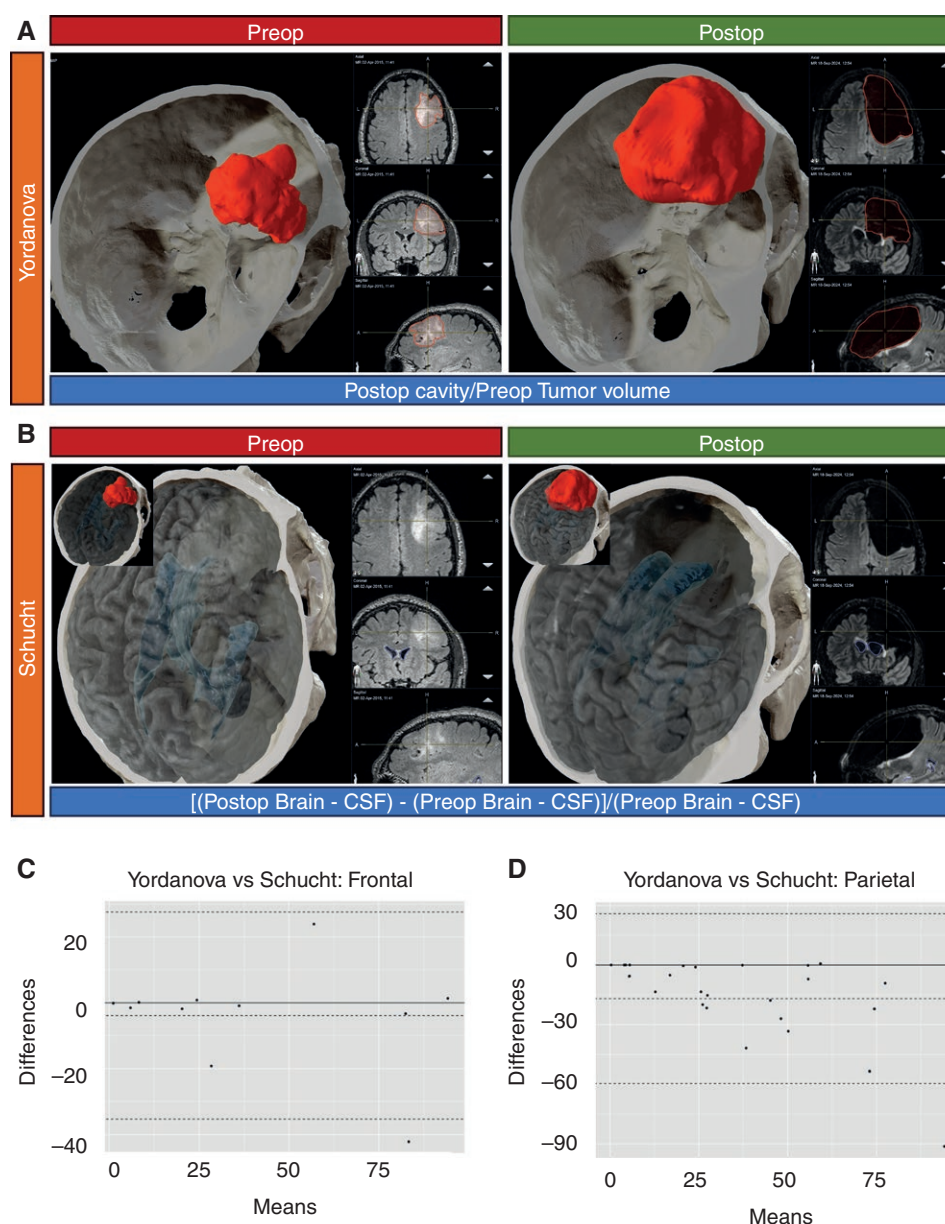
Assessment of SpTR. (A–B) measurement of SpTR: modified-Yordanova's and Schucht's methods in a representative case of right frontal LGG. With modified-Yordanova's (A) the post-surgical cavity and the tumor volume are calculated by a semi-automated segmentation procedure applied to 1-month post- and preoperative 3D-FLAIR. In the Schucht's (B) the brain volume is calculated onto the preoperative 3D-FLAIR and 1-month post-3D-FLAIR, by a semiautomated segmentation procedure, considering the entire brain volume and subtracting the CSF space. In both cases, SpTR is achieved when the post-surgical cavity volume exceeds the tumor volume. C,D) comparison of the measurements obtained by modified-Yordanova's and Schucht's in frontal (C) and parietal (D) tumors; the superposition was good in case of frontal tumors; in parietal tumors modified-Yordanova's underestimated the cases of SpTR and 64% of cases judged as TR were re-considered as SpTR by Schucht's.
